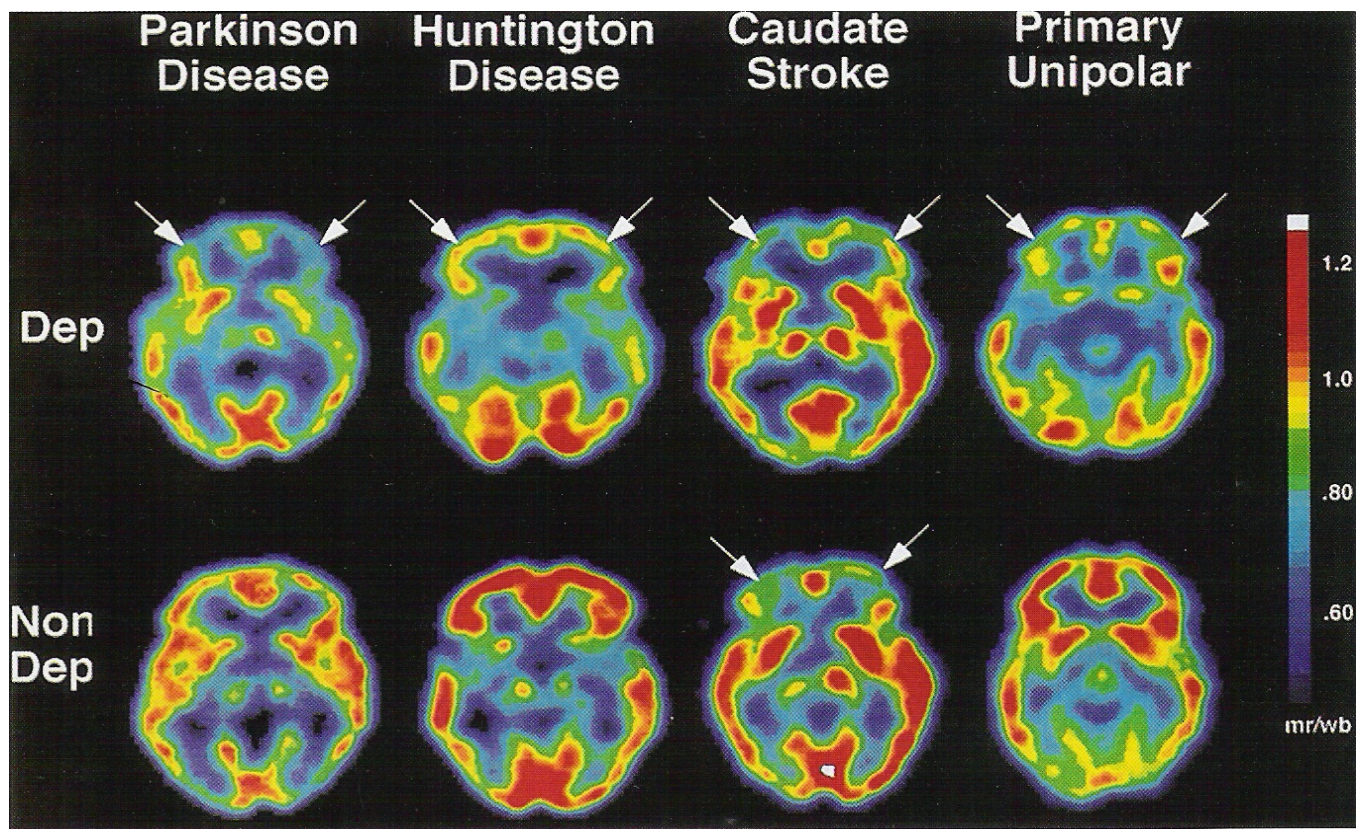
Single photon emission computed tomography (SPECT)  $^{99m}\text{Tc}$ -hexamethylpropyleneamine oxime (HMPAO) images.
